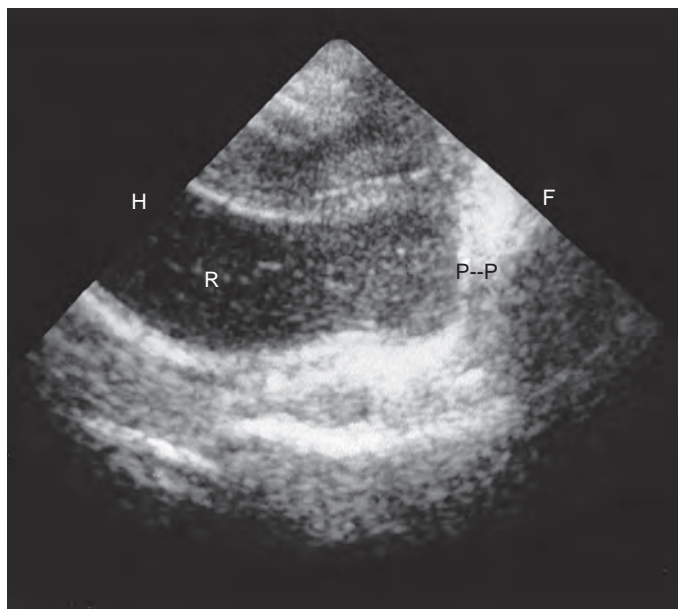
Imperforate anus. On a longitudinal sonogram of the rectal pouch in an infant with imperforate anus, the echogenic meconium distends and defines the distal rectal (R) pouch. The pouch-to-perineum distance (P-P) is only a few millimeters. F, inferior; H, superior.
